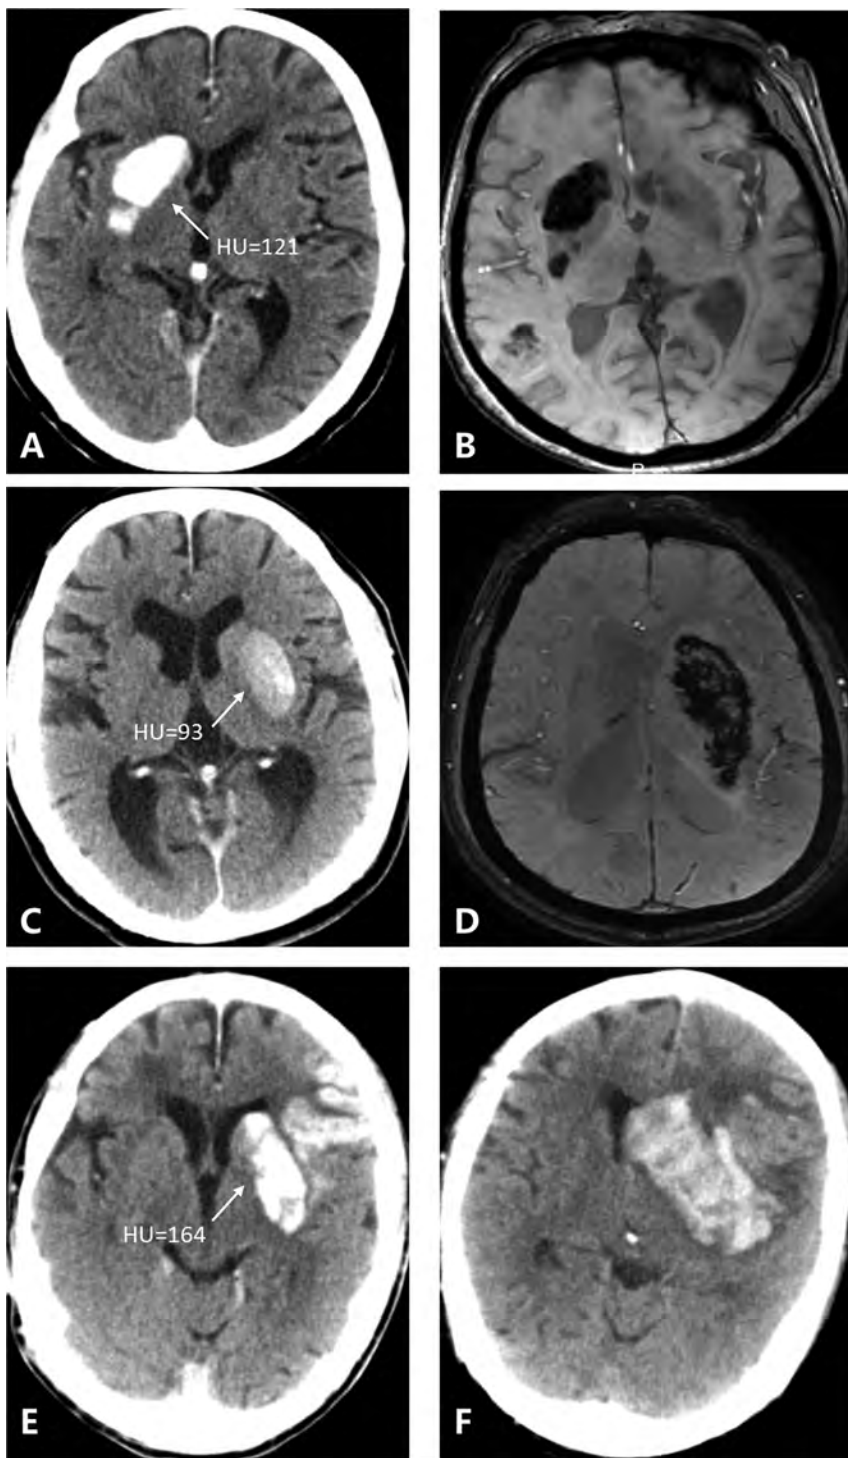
Three patients with 3 kinds of metallic hyperdensity signs. A, C, and E, NCCT images obtained immediately after mechanical thrombectomy. B and D, SWI at 24 hours after mechanical thrombectomy. F, NCCT image at 24 hours after mechanical thrombectomy. A 77-year-old woman with a hyperdense lesion and a maximum CT density of 121 HU in the right caudate nucleus on NCCT images immediately after mechanical thrombectomy (A) has parenchymal hemorrhage on SWI at 24 hours (B). A 71-year-old man with a hyperdense lesion and a maximum CT density of 93 HU in the left lenticular nucleus on NCCT images immediately after mechanical thrombectomy (C) has parenchymal hemorrhage on SWI at 24 hours (D). An 81-year-old man with a hyperdense lesion and a maximum CT density of 164 HU in the left lenticular nucleus on NCCT images immediately after mechanical thrombectomy (E) has parenchymal hemorrhage on the NCCT image at 24 hours (F).
